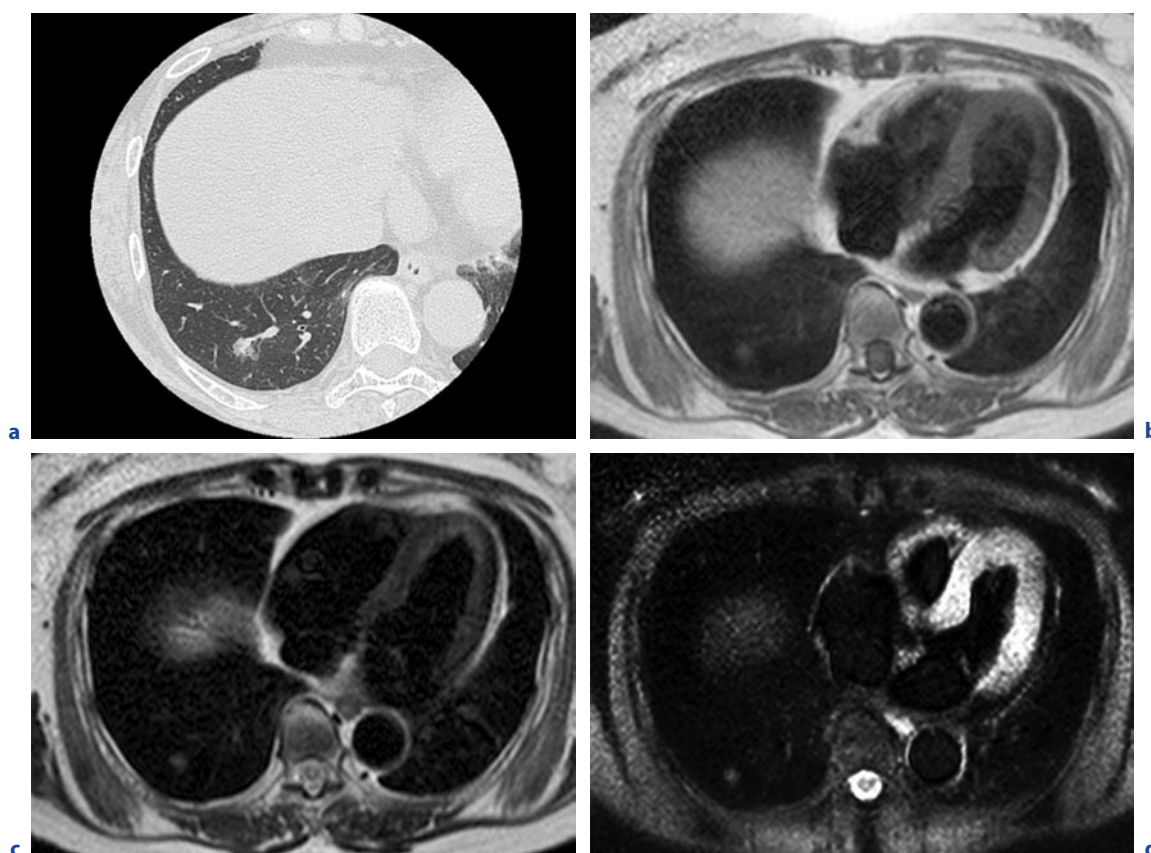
A 71-year-old female with adenomatous hyperplasia in the right lower lobe. Thin-section CT indicates ground-glass attenuation in the right lower lobe (a). Black-blood T1-weighted turbo SE (b), T2-weighted turbo SE (c) and STIR turbo SE (d) images show a nodule as, respectively, low, intermediate and high signal intensity in the right lower lobe
